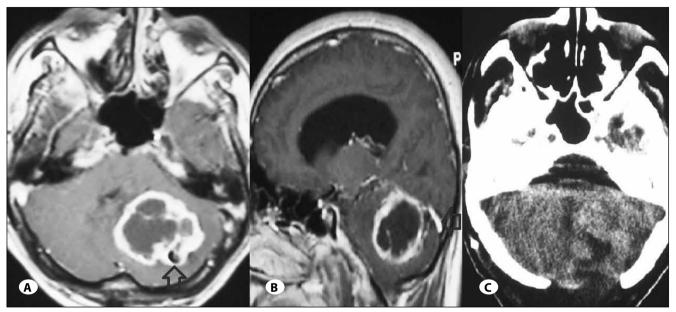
A) Axial CT section with contrast showing left cerebellar hypervascular lesion (arrow). B) Sagittal T1-weighted MRI of the cranium with contrast showing the lesion and arterial feeding (arrow). C) Postoperative axial CT section showing the lesion, which were totally removed.
